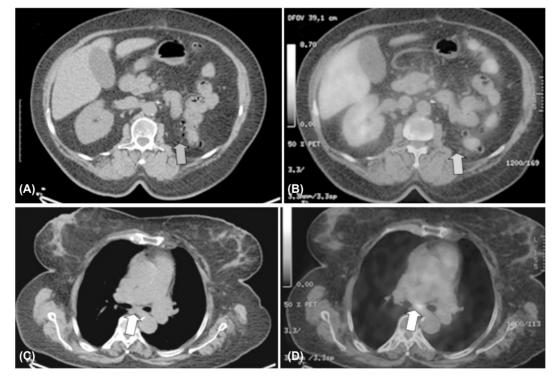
Axial CT and fused PET-CT images for a 65 year female patient with history of treated left renal cell carcinoma by left nephrectomy followed by chemotherapy.
